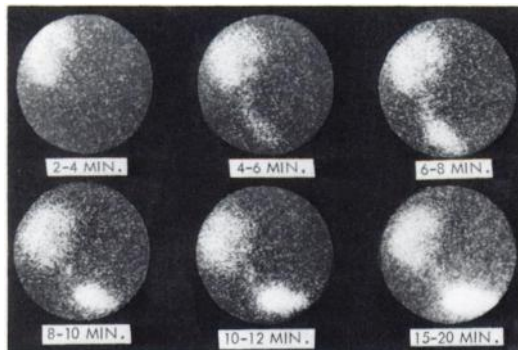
Normal renal transplant scintigraphic study using $^{131}\text{I-Hippuran}$. Time after tracer injection is given below each scintiphoto. Kidney in right iliac fossa, ureter, and bladder are seen.
